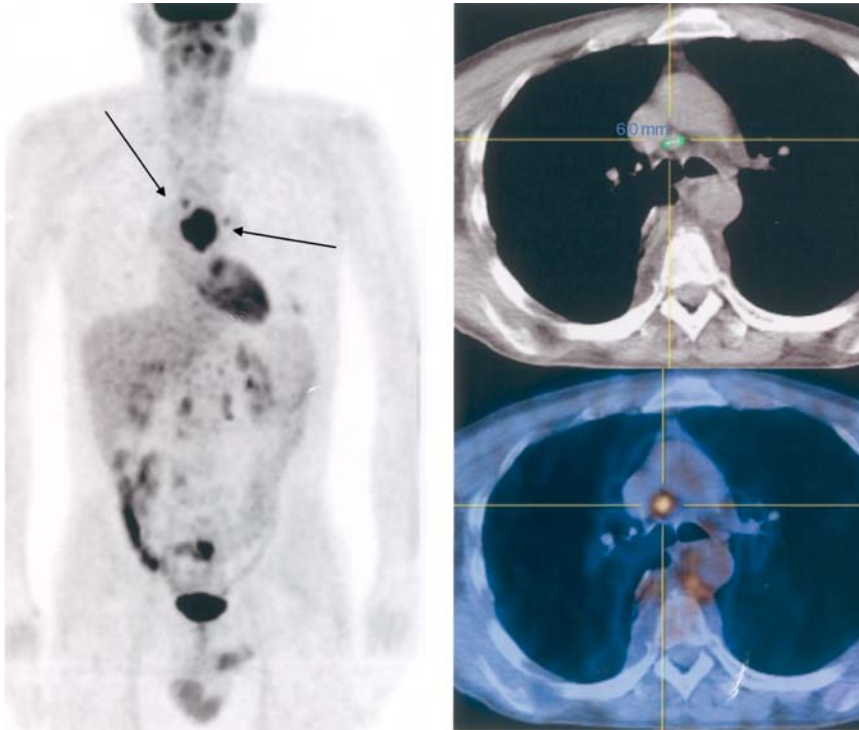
18F-FDG-PET/CT evaluating a patient with esophageal cancer at diagnosis. MIP Image (left side – arrows) shows primary positive mass and two tiny mediastinal positive nodes. CT axial slice (right, upper image) shows a 6 mm carinal node, negative for neoplastic involvement according to CT criteria. The same lymph node shows increased metabolic activity at the correspondent PET/CT axial slice (right, lower image) and is therefore a positive finding (N+)
